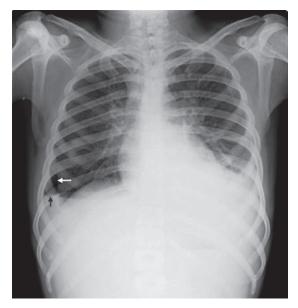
Erect chest X-ray shows pneumothorax on right side (white arrow) at the inferior end of pneumothorax is a small air fluid level (black arrow) making the diagnosis as hydropneumothorax
